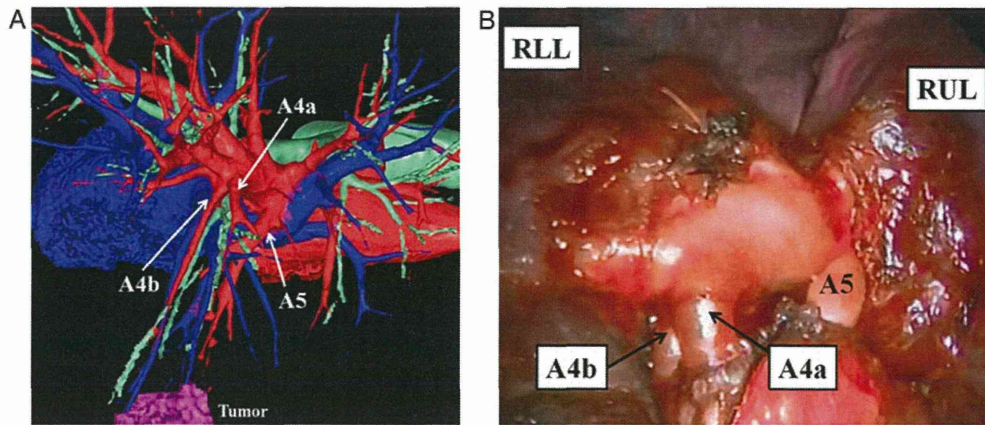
(A) The 3-dimensional computed tomographic image of the right pulmonary vessels showed that this patient had triple middle lobe pulmonary artery branches. (B) The intraoperative findings of this patient showed triple middle pulmonary artery branches corresponding to the 3-dimensional computed tomographic image.
